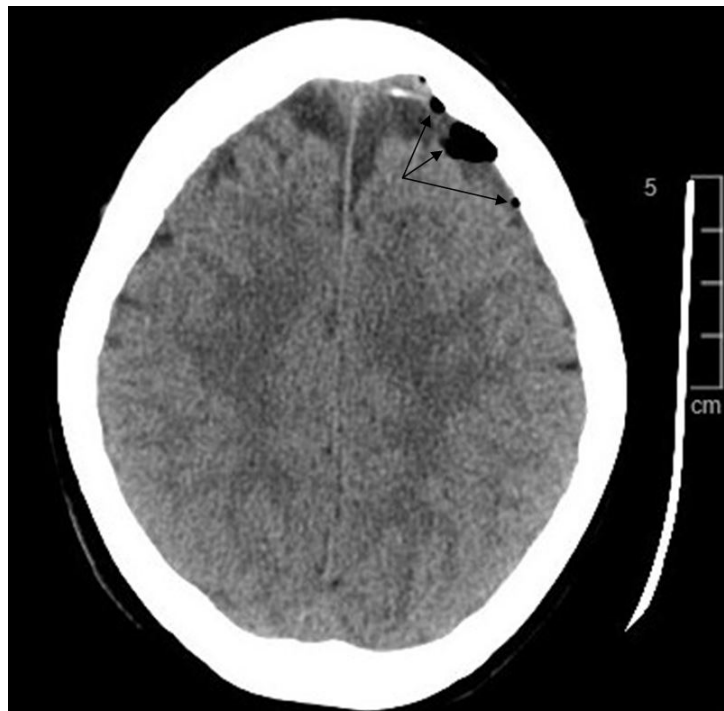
CT scan of brain with pneumocephalus, seen as black colour locules of air (Rashid et al. 2018)
